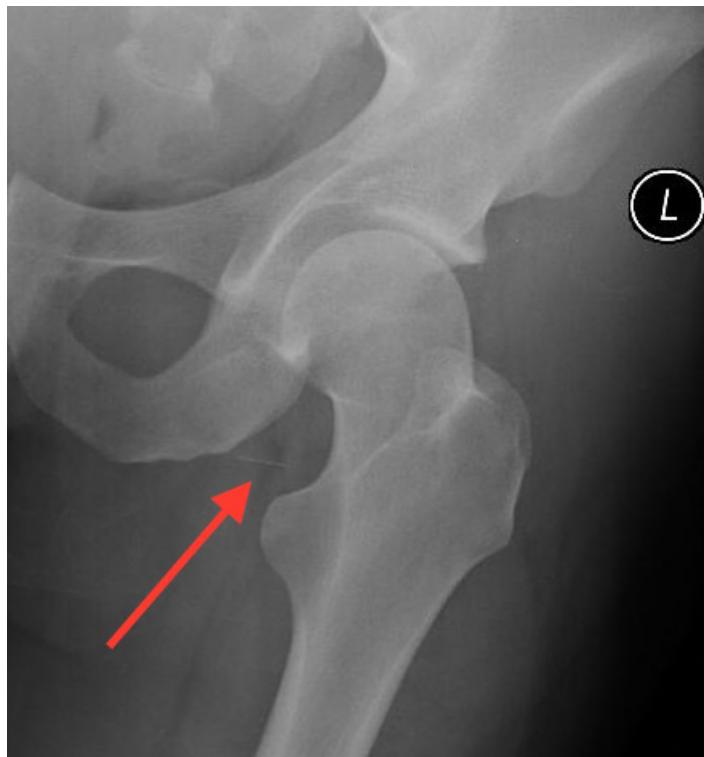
Linear foreign body (arrow) in the groin as seen on plain radiograph.
